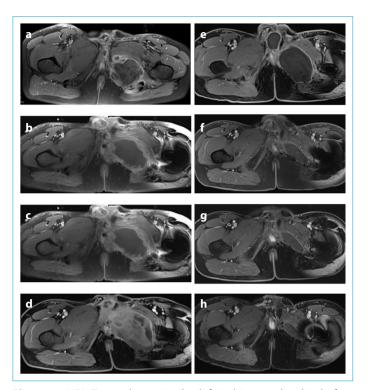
MRI. Tumor lesion in the left ischium and pubis before (a) and after surgery (b), or after (c) 2 months, (d) 5 months, (e) 11 months, (f) 18 months, (g) 21 months, (g) 33 months of the surgery. Lesion continued lessening.
